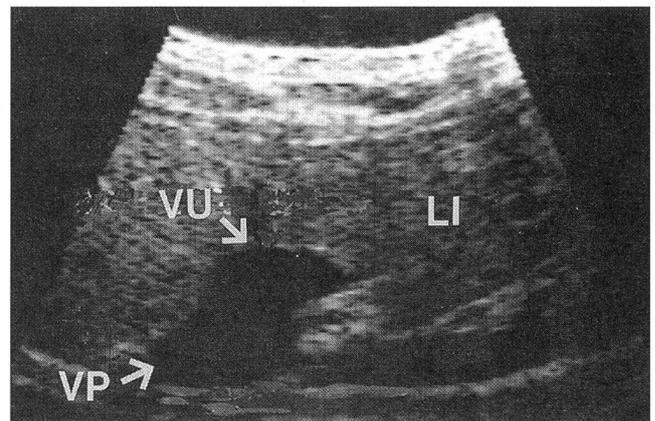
Ultrasonographic cross section through the umbilical vein (VU) at its union with the portal vein (VP) in the liver (LI) of a newborn calf (Position 9; see figure 4). The umbilical vein is completely surrounded by liver tissue.
